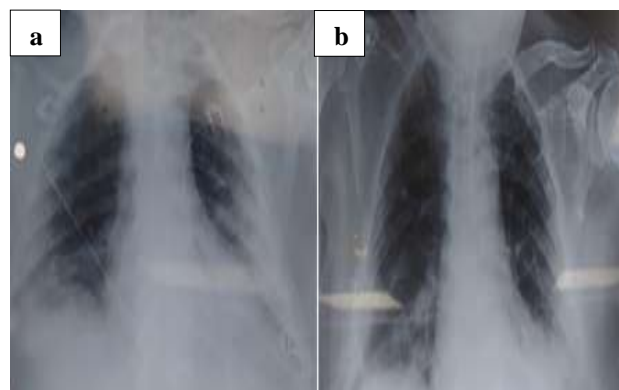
Chest x-ray (a) on day 17: pre-intubation - bilateral fluffy shadows seen all over the lung (left > right) with obliteration in the costophrenic angle bilaterally and (b) on day 26: post-extubation - fluffy shadows seen in bilateral lower lobes (left > right) with obliteration in the costophrenic angle on the left, an improvement is observed as compared to the previous X-Ray.
